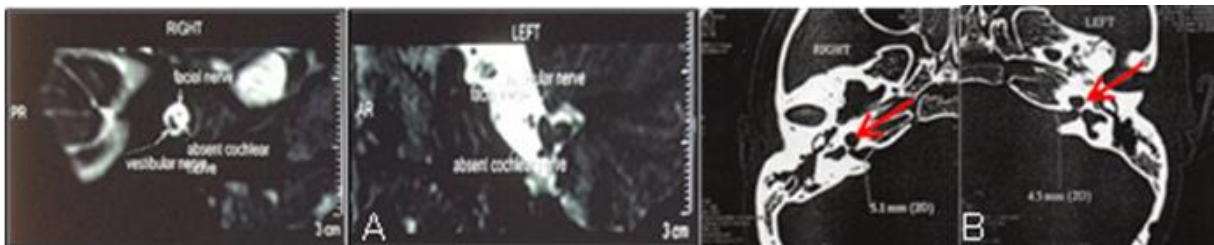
(A) MRI and (B) CT scan result of patient in case 3.
